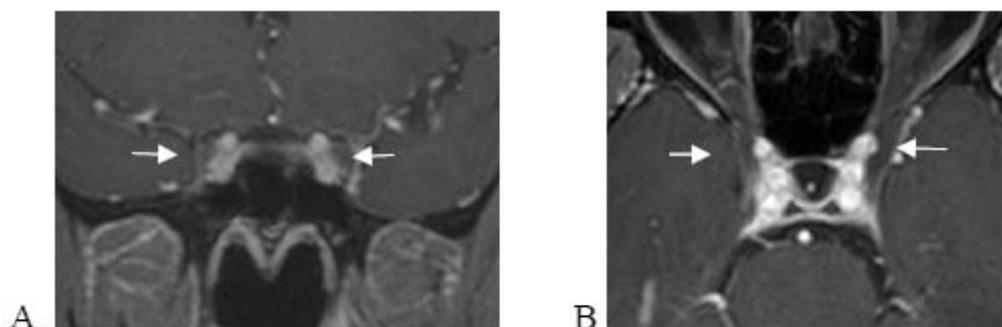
Case 7: chronic inflammatory demyelinating polyneuropathy (CIPD): A 42-year-old male presented with a 1 year of progressive left ptosis and ophthalmoplegia. Coronal (A) and axial (B) MRI of the brain and orbits post gadolinium T1WI shows abnormal enlargement of the intracavernous portions of bilateral CN III continuous to bilateral orbital apices, predominately on the left (white arrow).
